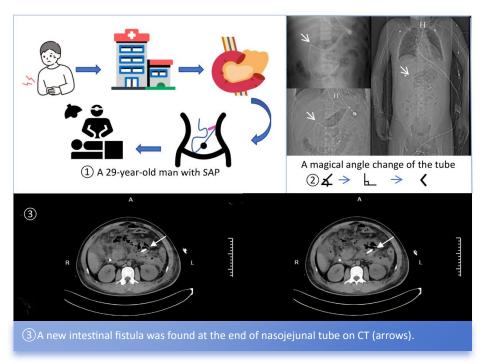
Radiographic changes of the right upper abdomen of the nasointestinal tube indicated duodenal perforation.
